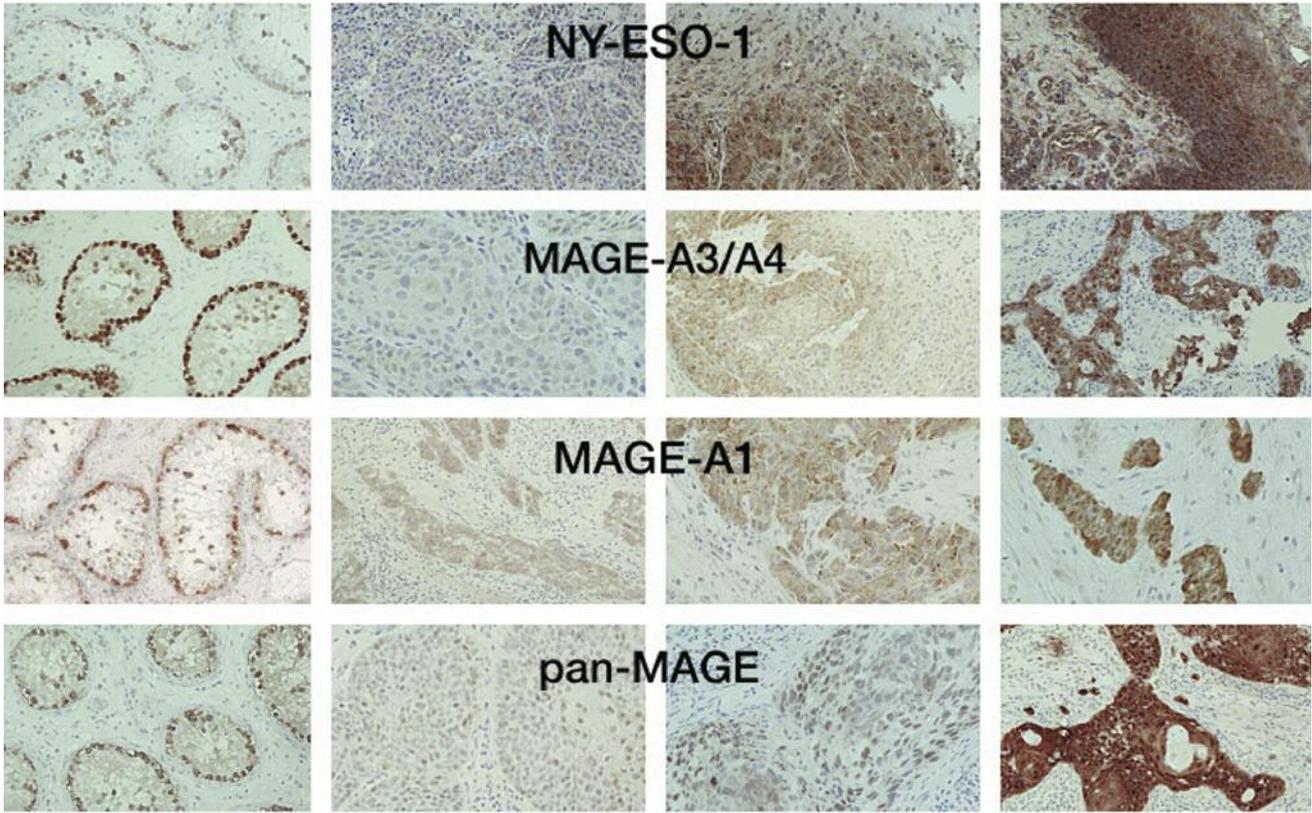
Expression intensity of the CTA antigens. First column shows the positive controls (testicular tissue), second column presents a weak expression intensity (1+), third column with a moderate (2+) and fourth with the highest intensity (3+). MAGE, Melanoma-associated antigen; NY-ESO-1, New York esophageal squamous cell carcinoma 1.
